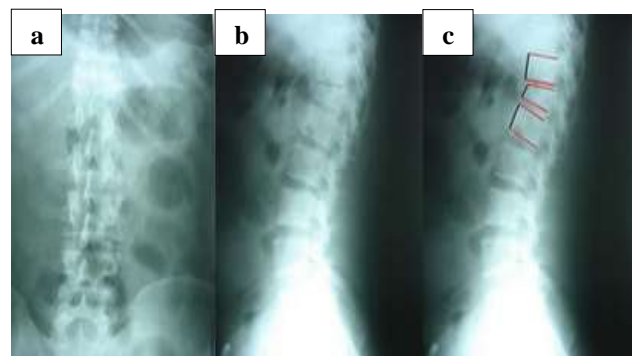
Case 2 (a), (b) and (c) pre-operative x-ray shows anterior wedge compression of D12.
